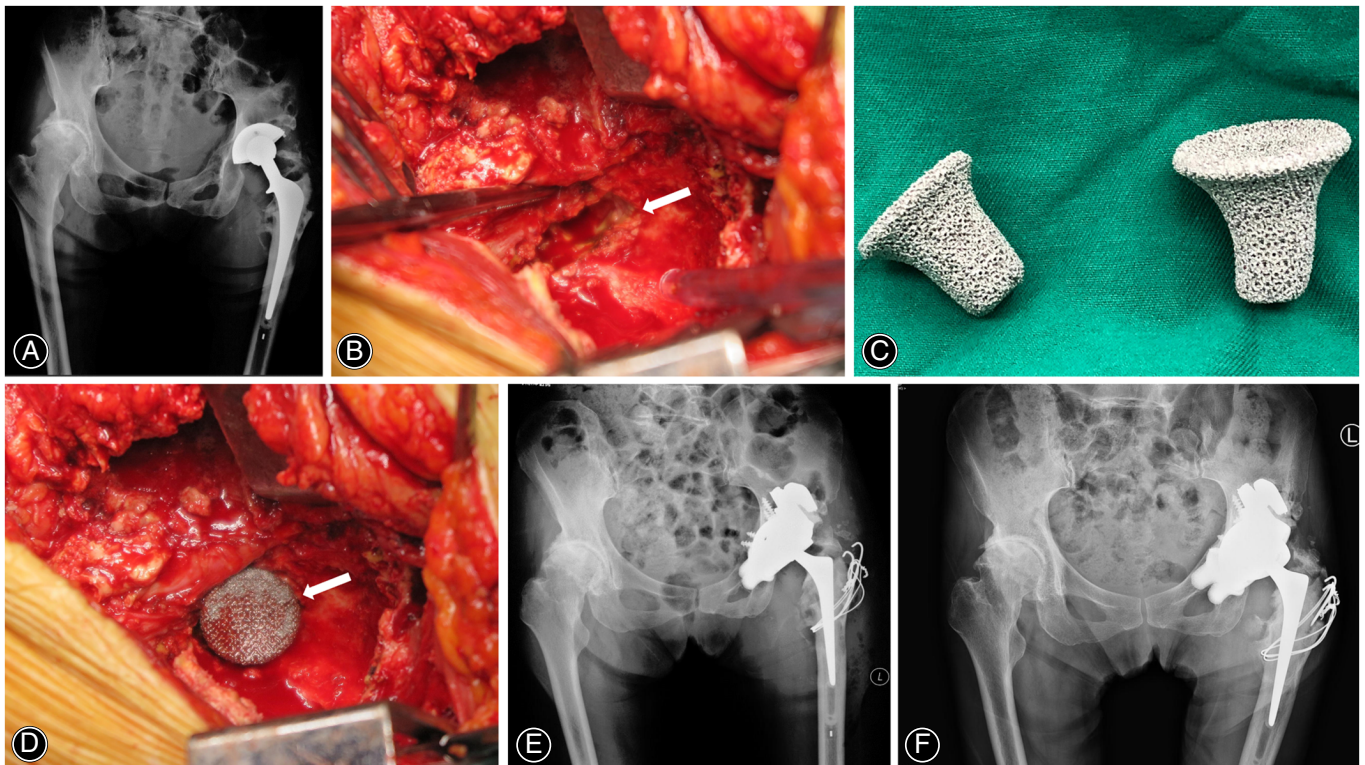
A representative case of extended ischiopubic fixation using porous metal lotus augments. (A) Preoperative anteroposterior radiograph of the pelvis of a 70-year-old female with Parkinson's disease demonstrating substantial ischial and pubic osteolysis in the left hip. (B) Intraoperative photo demonstrating substantial osteolysis in the anteroinferior pubis ramus (white arrow). (C) Intraoperative photo of the two lotus augments. (D) Intraoperative photo demonstrating a lotus augment press-fitted into the bone defect in the pubis (white arrow). (E) Immediate postoperative anteroposterior radiograph of the pelvis demonstrating two lotus augments press-fitted into the ischium and pubic ramus to reconstruct two firm inferior supportive points (note that the trimmed TM Buttress augment was trimmed into two parts and secured in the ilium simultaneously to reconstruct one superior supportive point). (F) Postoperative anteroposterior radiograph of the bilateral hips with 2.6-year follow-up demonstrating a stable cup with bony fixation and no radiolucent lines around the construct
